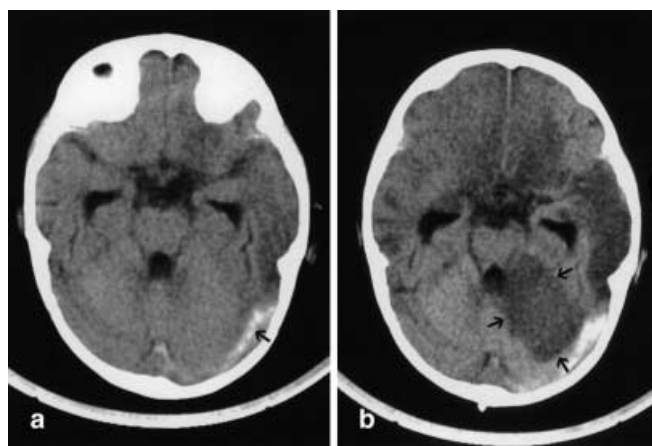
a CT scan misinterpreted as posterior fossa subdural haematoma (SDH), but in fact showing thrombus in the lateral sinus (arrow). b CT scan a day later shows the presence of thrombus, with extensive infarction of the cerebellum (arrows)
